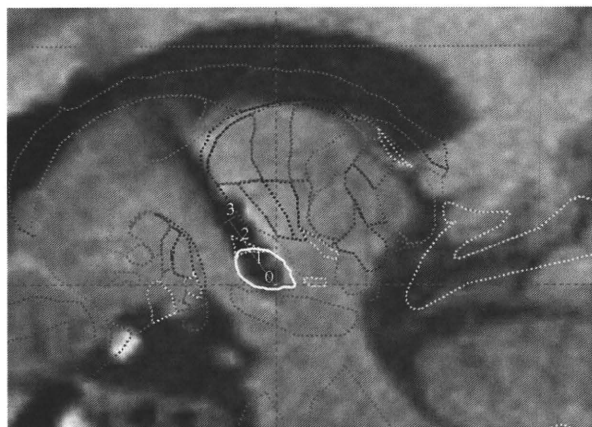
Postoperative T₁-weighted magnetic resonance image showing contacts placed in the subthalamic nucleus and the area above this nucleus.
